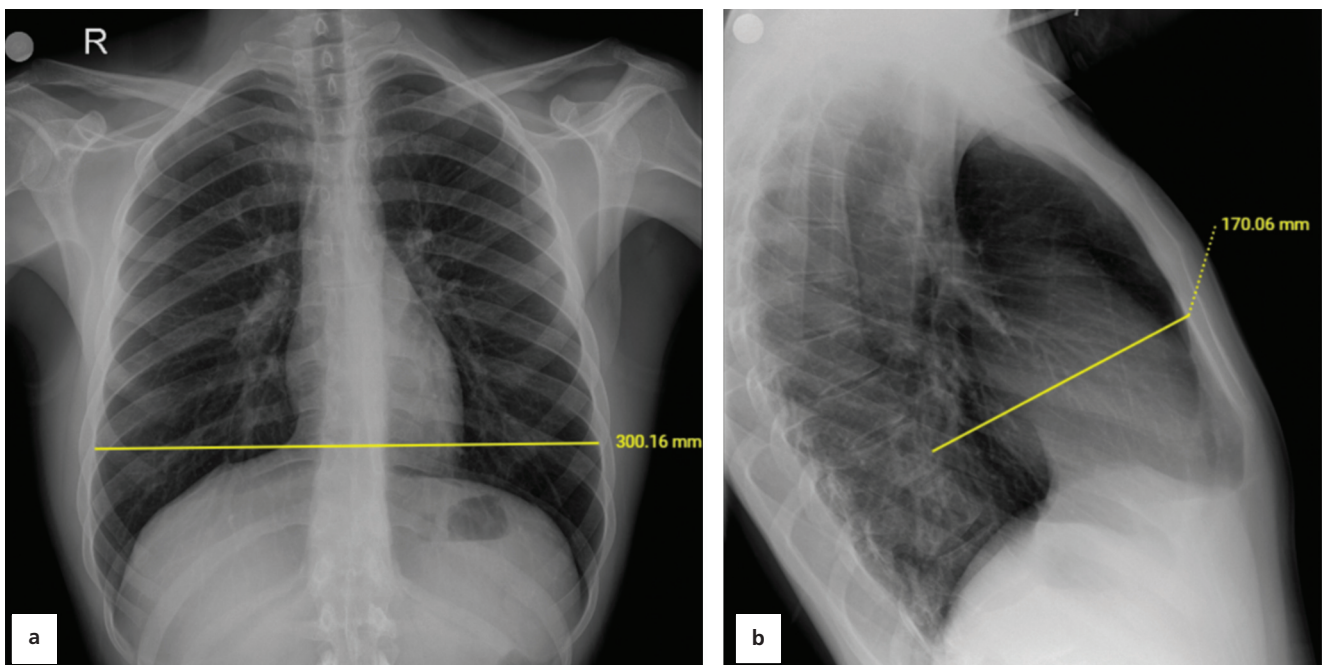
Posteroanterior (a) and lateral (b) two-view chest radiography of a 21-year-old male with pectus carinatum. Haller index was calculated as 1.76.
